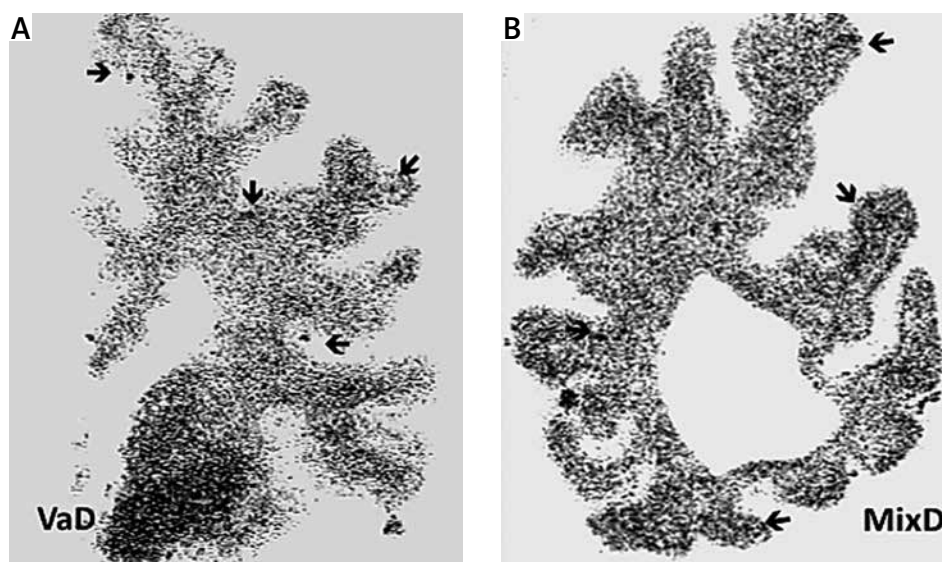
T2* MRI demonstrating the presence of cortical microbleeds (arrows) on a coronal section of the frontal lobe in a patient with vascular dementia (A) and of the occipital lobe in a patient with mixed dementia (B).
